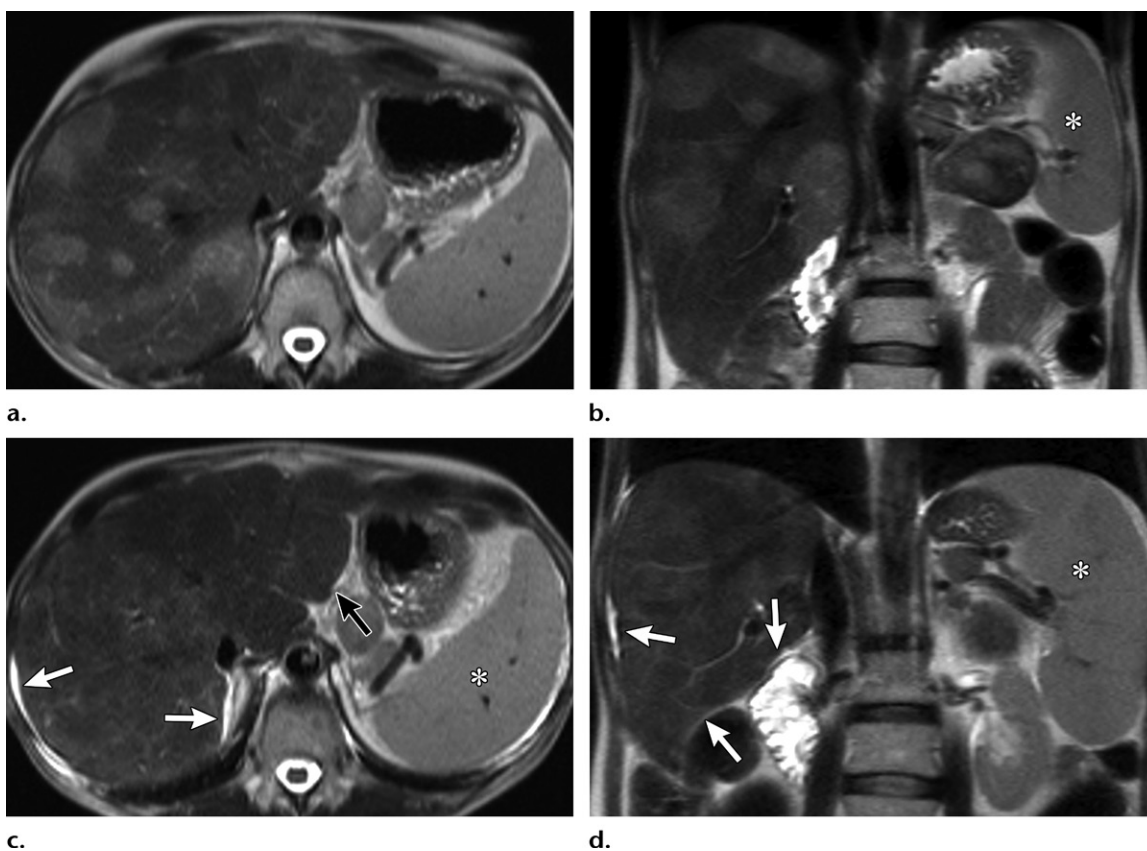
Fibrosis and portal hypertension in a 43-year-old woman with liver metastases from a neuroendocrine tumor. (a, b) Axial (a) and coronal (b) T2-weighted pretreatment MR images show multiple liver metastases. Note the normal size of the spleen (* in b). (c, d) Axial (c) and coronal (d) T2-weighted post-TARE MR images show reduced lesion size and lobulation of the right lobe (white arrows), with mild enlargement of the left lobe (black arrow in a). Splenomegaly (*), a manifestation of portal hypertension, also is seen.
